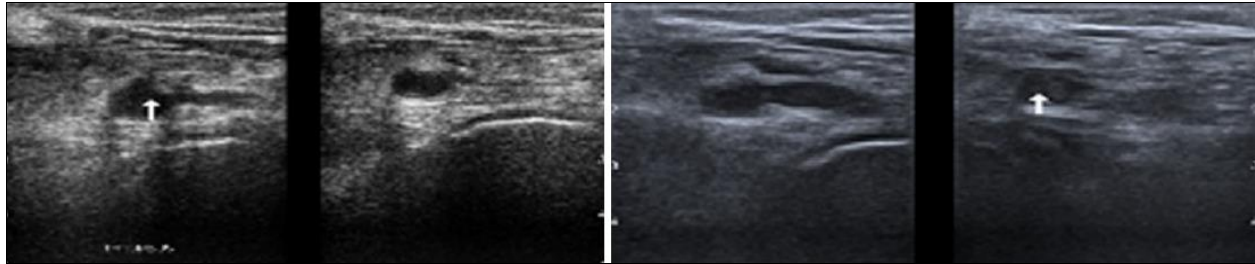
Atherosclerotic changes in the common iliac artery, with no flow in anterior and posterior tibial artery and dorsal pedis artery on doppler ultrasound
